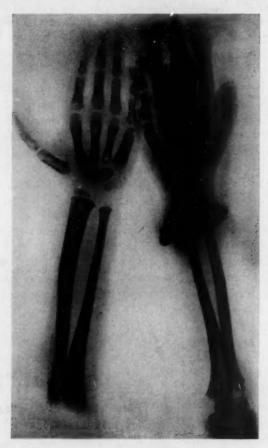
Roentgenogram of the hands and forearms of a 6 year old girl who had acquired yaws two years previously. She was given injections at that time, but osseous lesions and ulcerative cutaneous lesions developed a year later and persisted. This roentgenogram was made at the Kingston (Jamaica) Hospital and given to me by Dr. T. B. Turner, of the Rockefeller Foundation. No secondary frambesiform lesions of the skin were then present, but Dr. Turner had no doubt as to the diagnosis.
